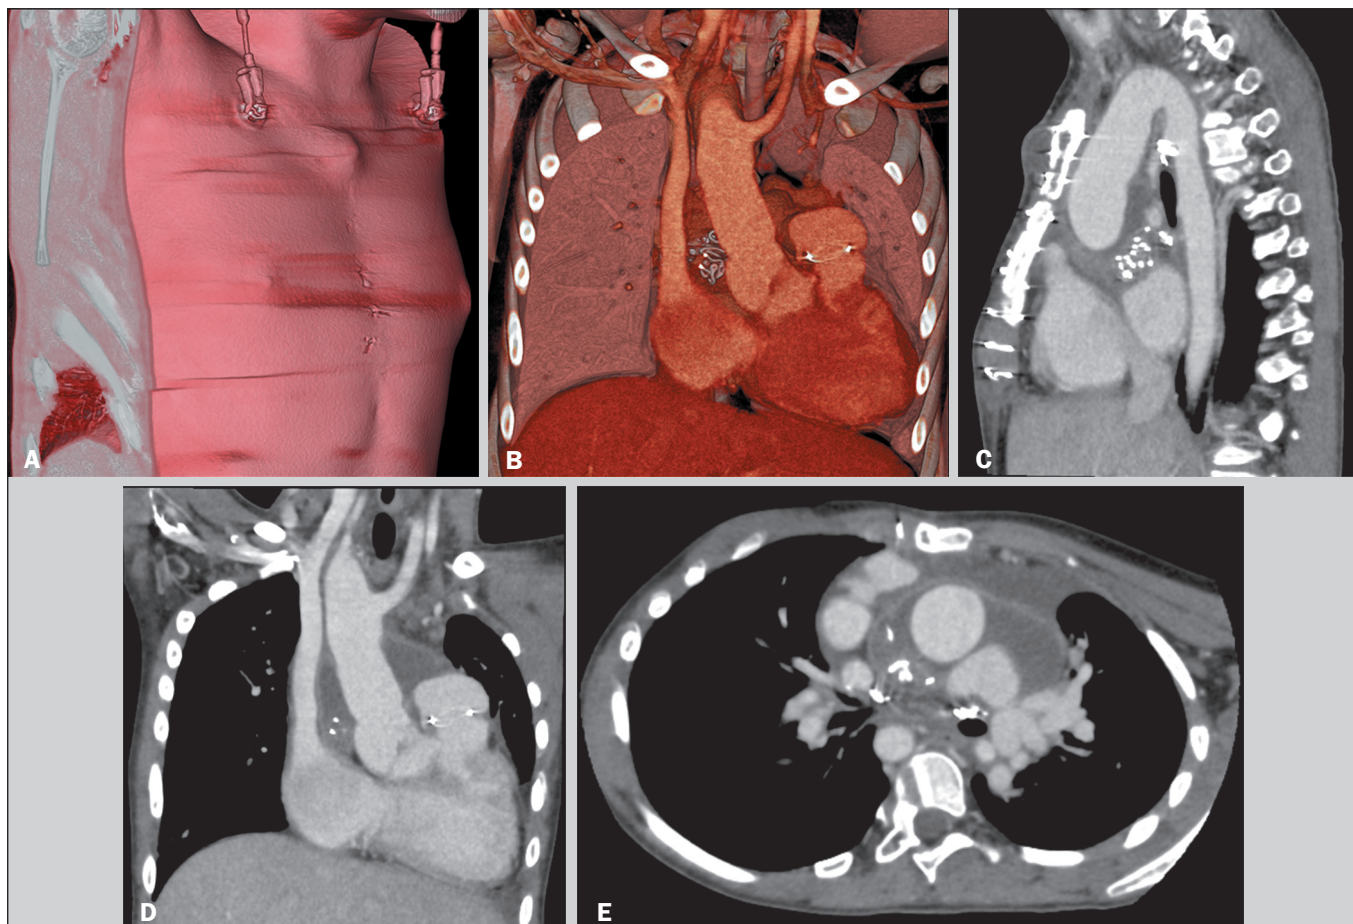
A 13-year-old girl with a history of pulmonary atresia and ventricular septal defect underwent corrective surgery. She developed postoperative fever and an increase in soft-tissue volume in the surgical wound. She was referred for contrast-enhanced chest computed tomography. Volumetric rendering of three-dimensional reconstructions (A,B), together with the sagittal, coronal, and axial images (C, D, and E, respectively), revealed the following in the presternal compartment: soft-tissue incision with opposing margins; and a subcutaneous fluid collection, measuring 8 mL, in the superior portion. The sternal compartment showed the median sternotomy with opposing margins and intact, aligned transverse transsternal sutures. In the retrosternal compartment, there was mild pericardial effusion with pericardial wall thickening and enhancement, together with a heterogeneous area containing radiopaque marker suggestive of retained surgical material, located on the right side, posterolateral to the ascending aorta. A second sternotomy revealed purulent mediastinitis with a retained gauze adjacent to the ascending aorta.
